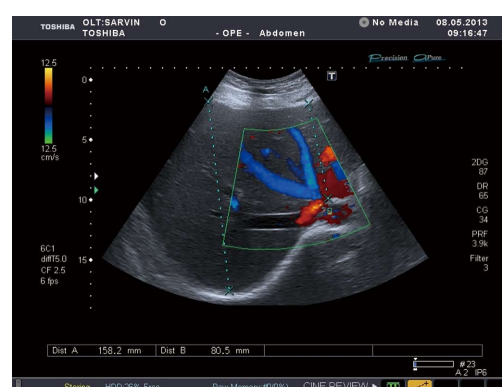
Ultrasound Doppler examination: Examination made 8 mo after liver transplantation. No changes in liver echogenecity. Hepatic veins: Walls not thickened, uniform lumen, blood flow preserved.
